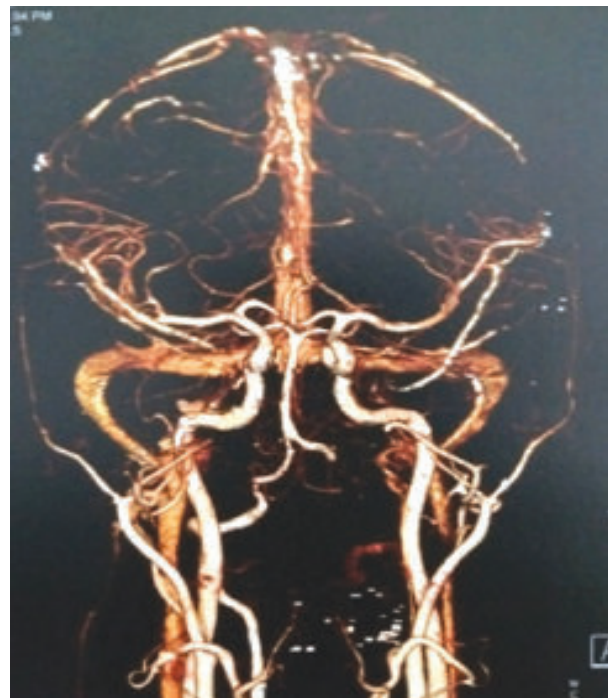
4: CT angiogram of neck vessels revealed total occlusion left vertebral artery
